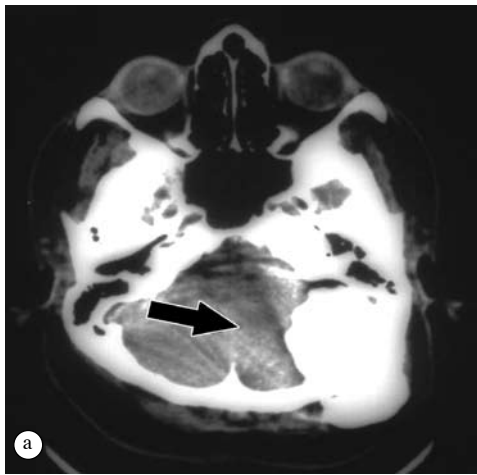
Non-contrast axial CT shows a) a calcified mass that is pressing on the cerebellum and, b) spreading out of the calvarium.
